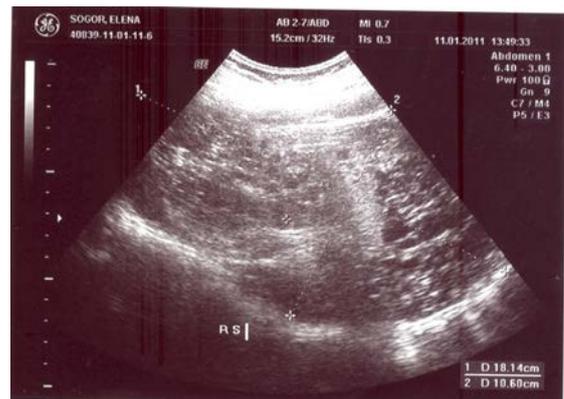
Renal ultrasound of the left kidney
